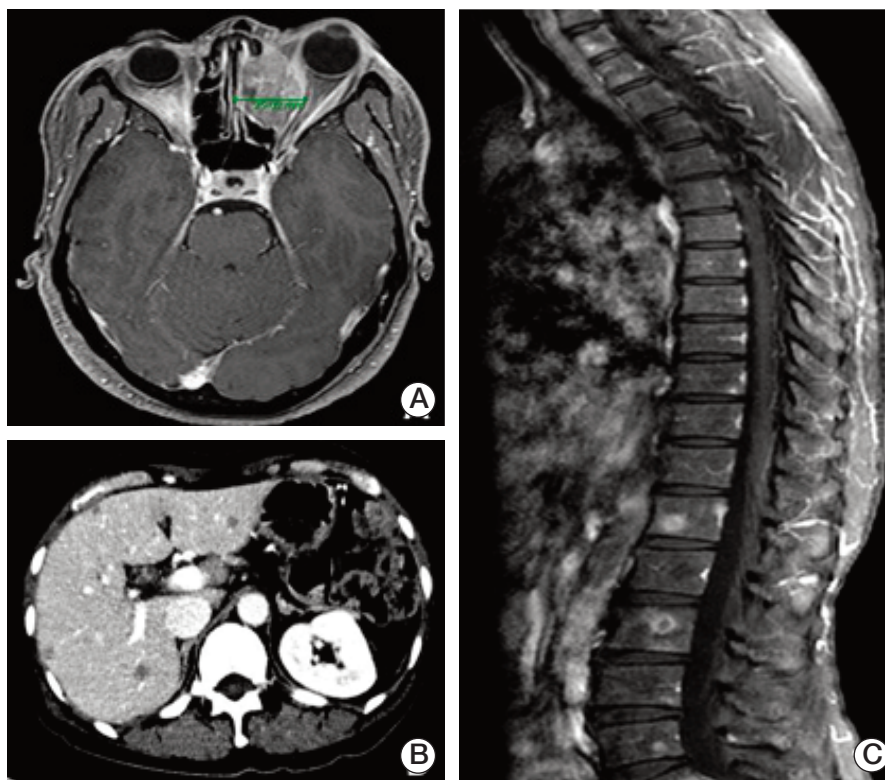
Imaging analysis of the patient. (A) Magnetic resonance imaging (MRI) of the paranasal sinuses shows an enhancing soft tissue lesion in the left frontoethmoid sinus extending to the left orbit. (B, C) Multiple metastases are seen in liver and vertebrae in the abdominopelvic computed tomography and spine MRI scan.
